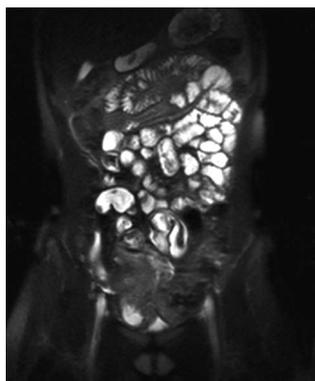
Hydro-magnetic resonance imaging using mannitol orally. Sometimes the filling result is inadequate and the distension of the bowel is insufficient.
